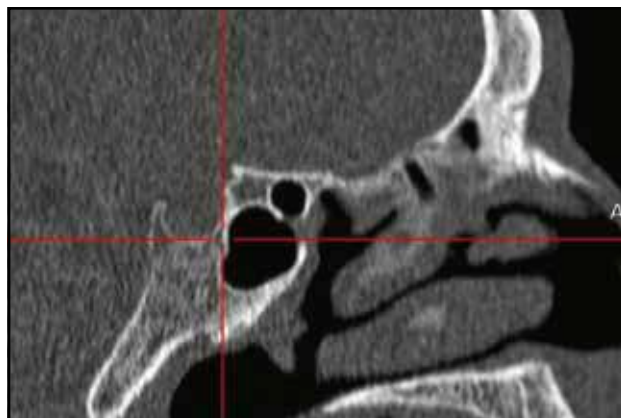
Presellar type pneumatization of the sphenoid sinus (cranio-facial CT scan, sagittal slice).
